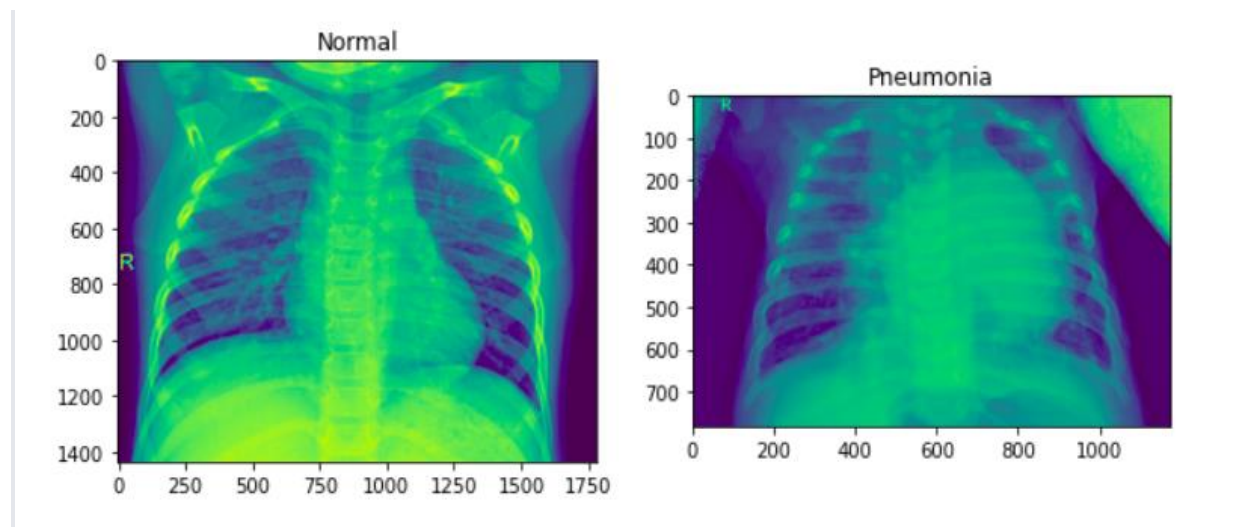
Representation of chest x-ray showing pneumonia and normal report
